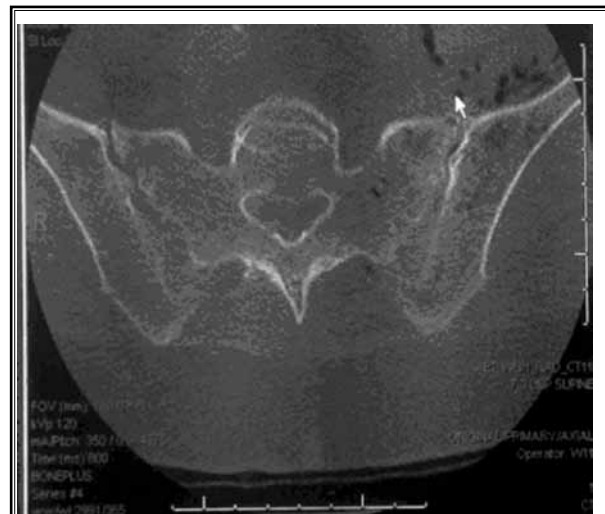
CT Image of Pelvis - gas around left SI joint and iliopsoas muscle
